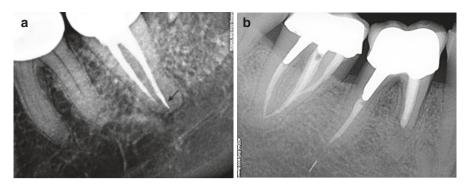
No intervention as the treatment option for fragments revealed randomly during full-mouth periapical radiographic examination. (a) According to the patient's history, the instrument fracture (*arrow*) occurred during RCT 15 years earlier. Prosthetic reconstruction was performed 5 years later. (b) The fragment in the periapical tissues can be attributed to the RCT performed, according to the patient's history, 16 years earlier. Since then, the patient experienced no pain or discomfort in the area
